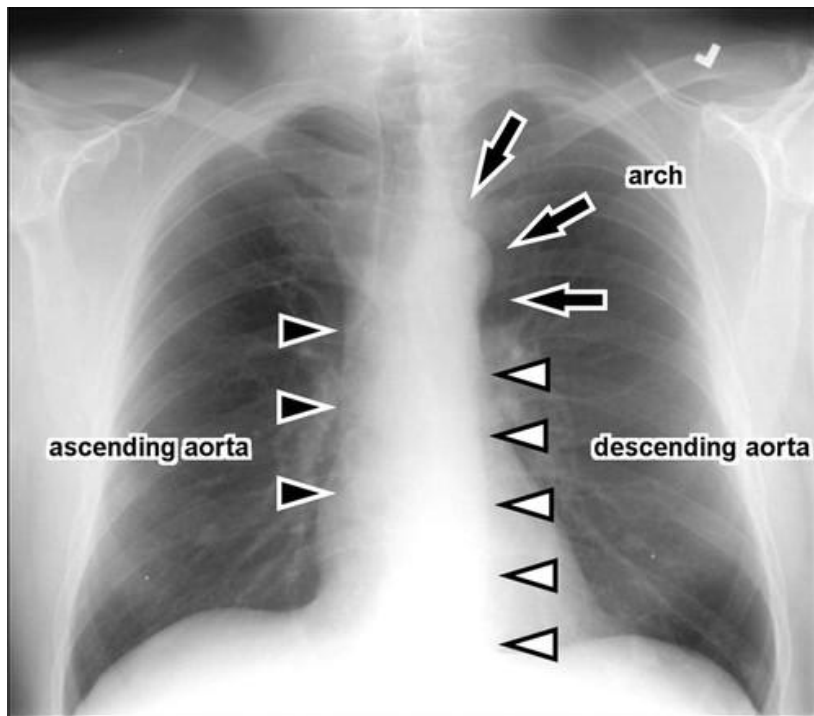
Plain radiograph of Aortic Dissection (9)
